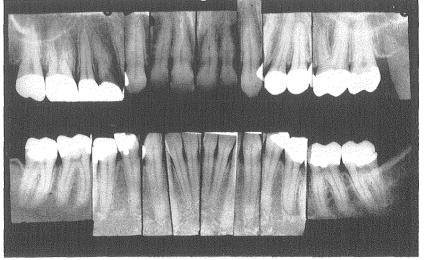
Roentgenograms taken 10 years after treatment.
